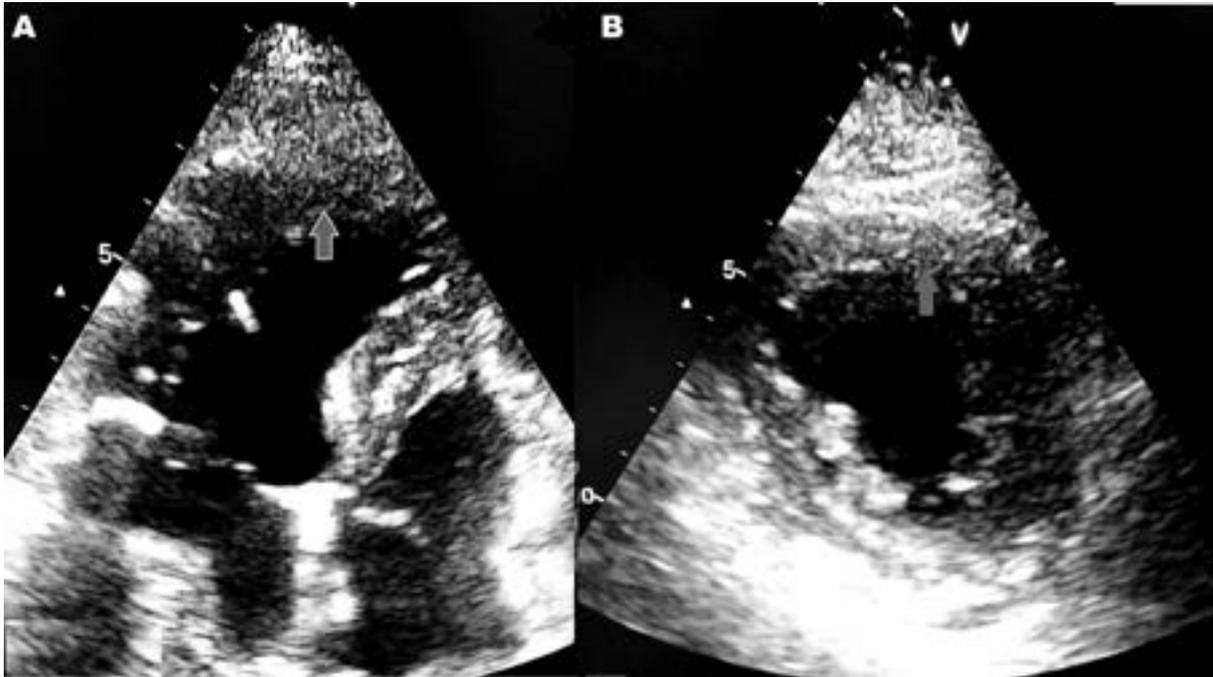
(A),(B) Echocardiography revealed hypokinesia in the apical and middle segments of the apex and left ventricle (red arrows), and was observed by preserving the basal segments
